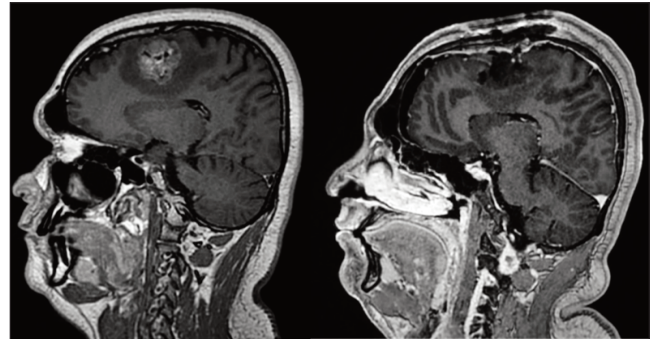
(Left) MRI brain with contrast (sagittal sequence) showing a contrast-enhancing intra-axial lesion within the pre-motor cortex, (Right) post-operative imaging showing gross-total resection of the lesion.
